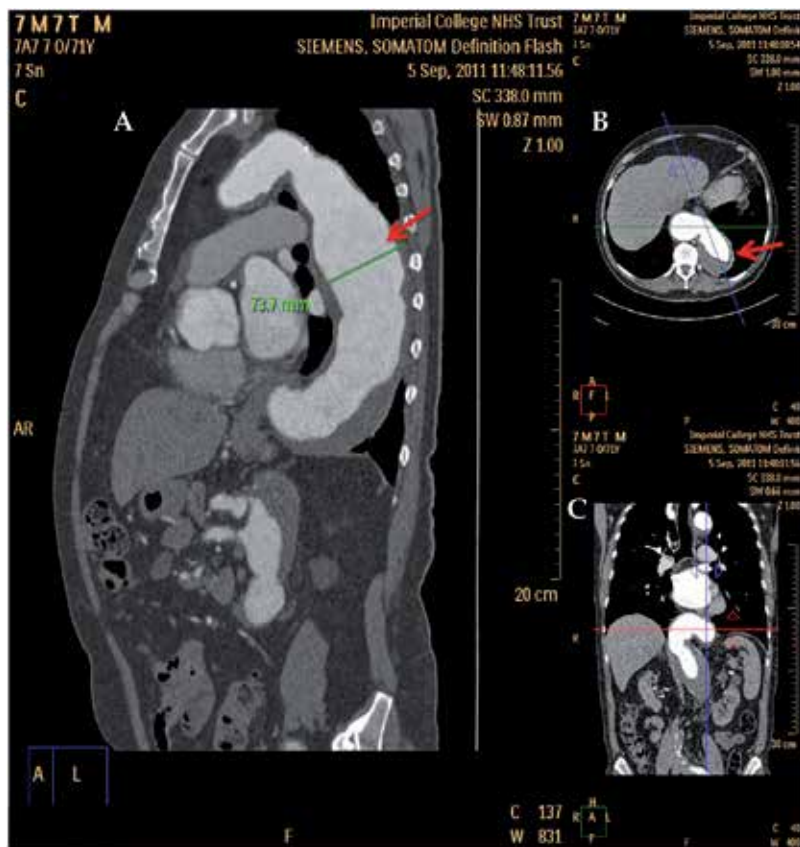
Thoracic aortic aneurysm CT angiogram of 7cm thoracic aortic aneurysm (arrow) in A) sagittal B) axial and C) coronal planes
